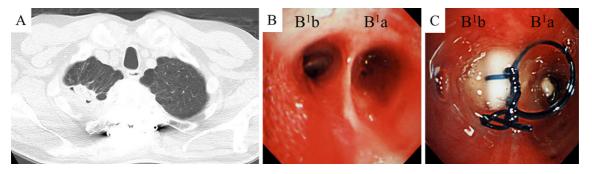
Chest computed tomography taken at admission. Spheroidal matter in the cavity of the right lung apex is shown (A). Bronchoscopic findings on days 6 (B) and 8 of hospitalization (C). Active bleeding from the right B¹a and B¹b is shown (B). In each bronchus, 7-mm spigots were placed using sutures for easy removal (C).
